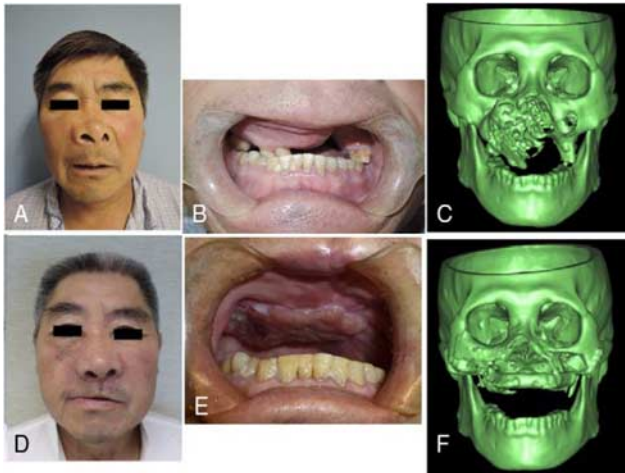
(A) Preoperative frontal view. (B) Preoperative intraoral view. (C) Preoperative computed tomography scan showing the extent of tumor. (D) Postoperative frontal view. (E) Postoperative intraoral view. (F) Postoperative three-dimensional computed tomographic scan.
